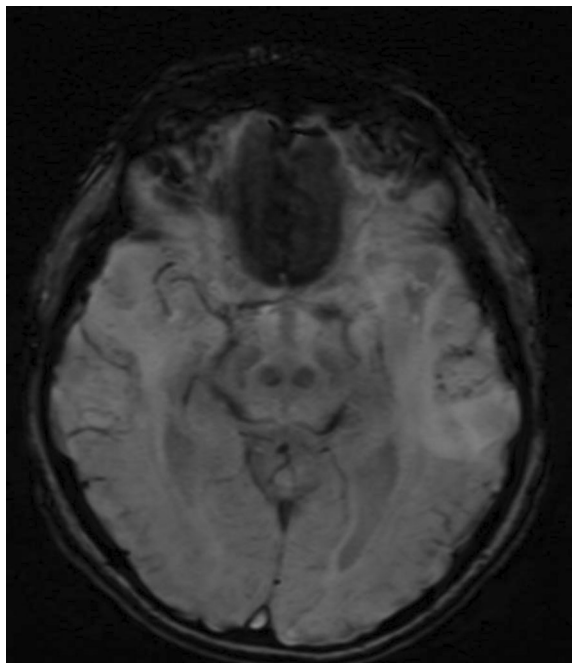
ARIA MRI SWI axial.
